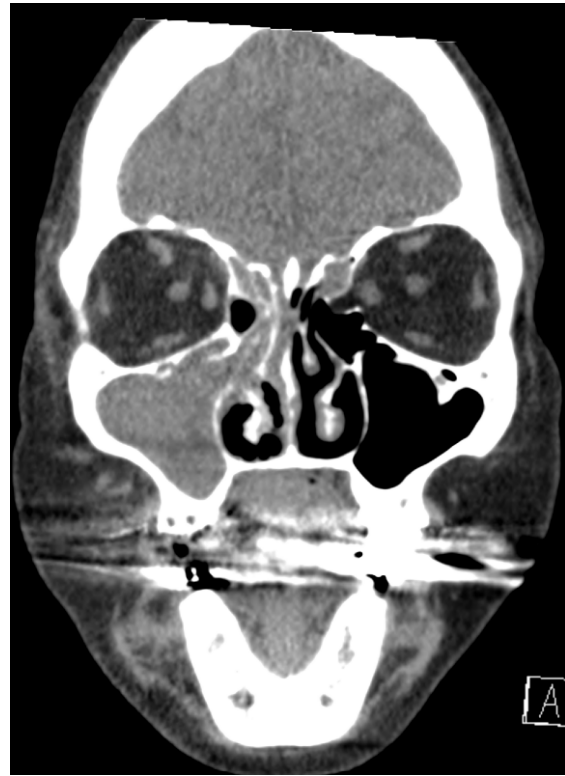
CT scan on presentation: Air-fluid levels and frothy appearance within the near completely opacified right maxillary sinus and right anterior ethmoid air cells. Partial opacification of the right frontal sinus with opacification of the right frontal recess.
